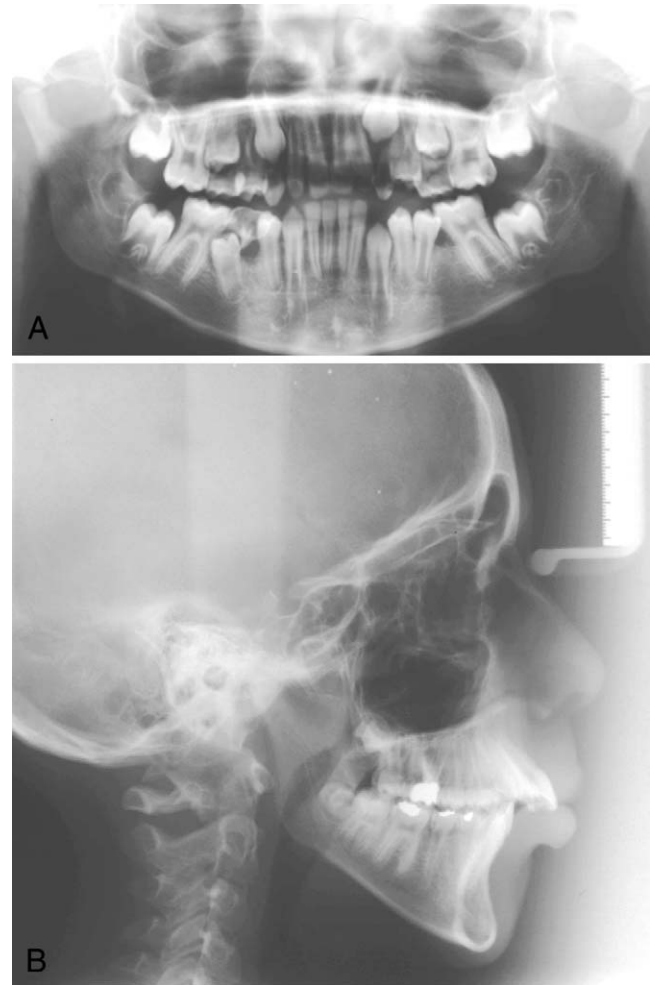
Pretreatment panoramic and cephalometric radiographs.
